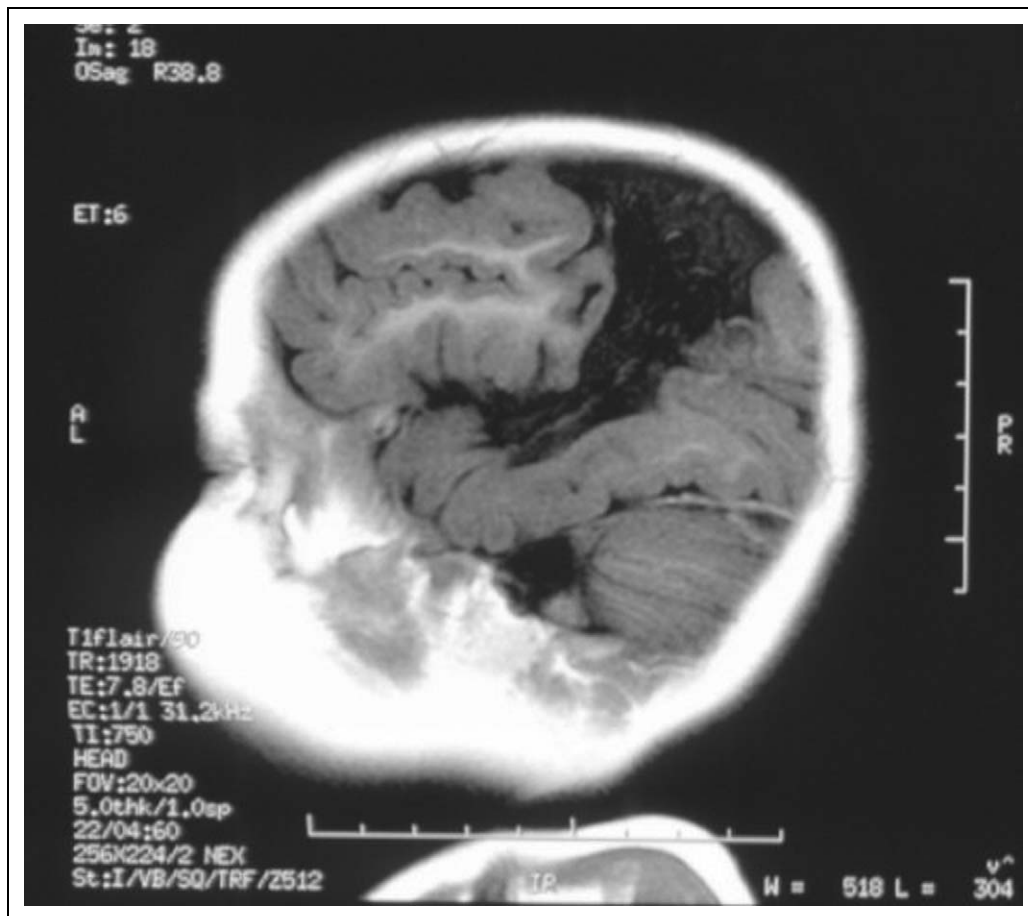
Image shows the T1 FLAIR sagittal magnetic resonance imaging (MRI) of the right hemisphere of our patient.
